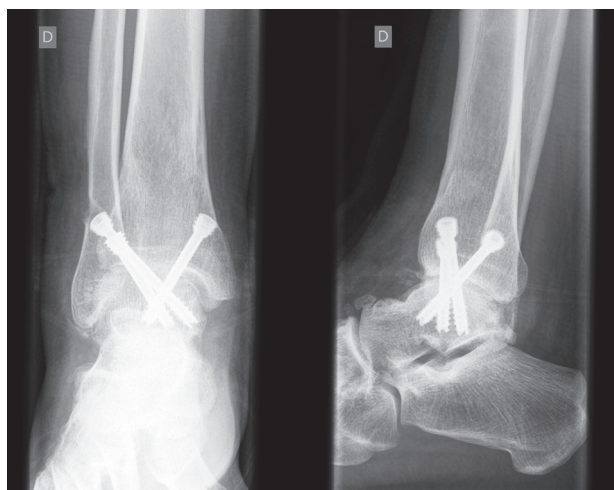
Post-operative x-ray of arthroscopic ankle arthrodesis with 3 screws, anterior-posterior (left) and lateral (right) view
